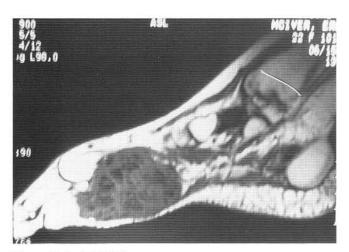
Sagittal MRI image.
